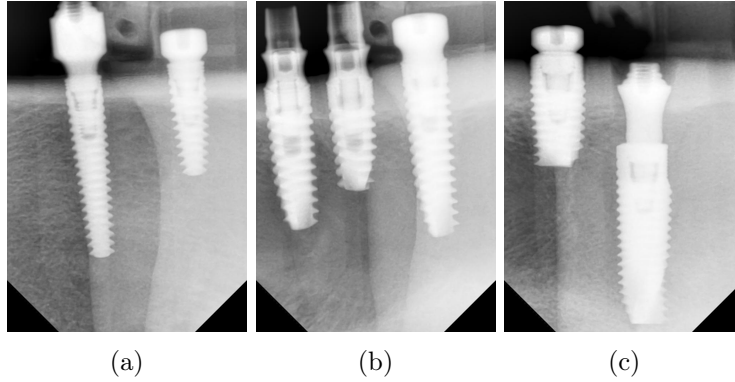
Examples of actual X-ray images containing dental implants.
